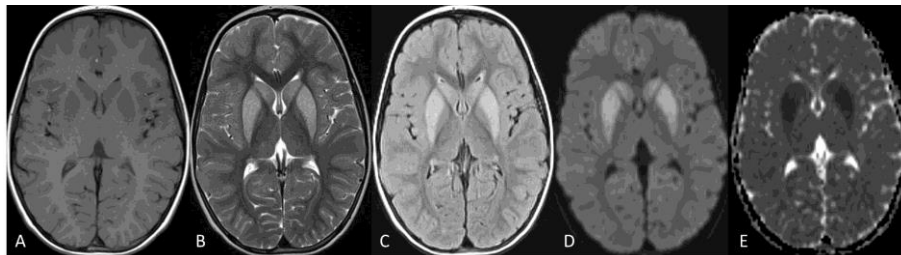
Brain MRI at age 3. Axial T1-weighted (A), T2-weighted (B) and FLAIR (C) images showing selective, bilateral and symmetrical mild hypointensity (A) and marked hyperintensity (B-C), of both caudate nuclei and putamina. The nuclei are slightly swollen. Axial diffusion-weighted imaging (DWI b1000; D), and apparent diffusion coefficient maps (ADC; E) show restricted diffusion of the nuclei, representing cytotoxic edema. Brain MRI at age 5 was unchanged (data not shown).
